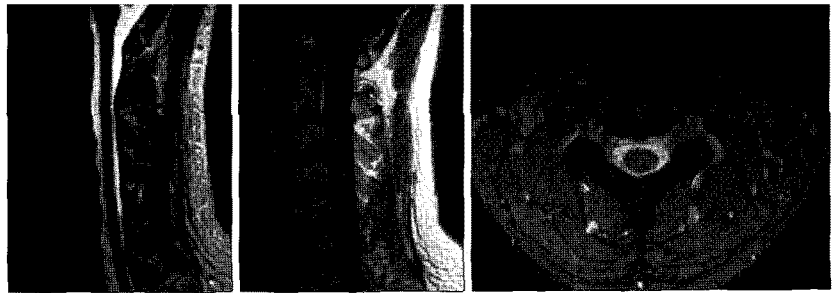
Follow-up MRI of cervical spine obtained 9 days after conservative treatment shows marked regression of cervical epidural venous engorgement compared with previous film.
